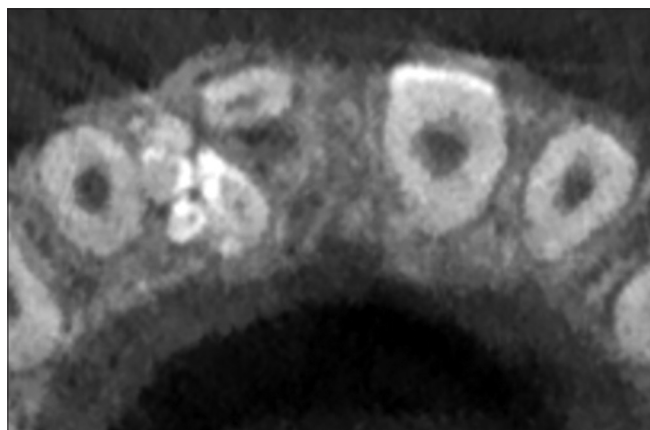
Axial section of cone-beam computed tomography
